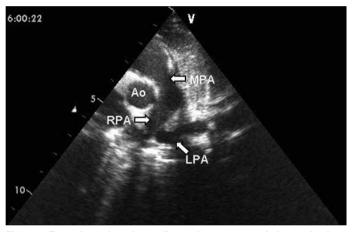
Transthoracic echocardiography, parasternal short axis view shows left pulmonary artery originating distal to its normal position Ao - aorta, LPA - left pulmonary artery, MPA - main pulmonary artery, RPA - right pulmonary artery
